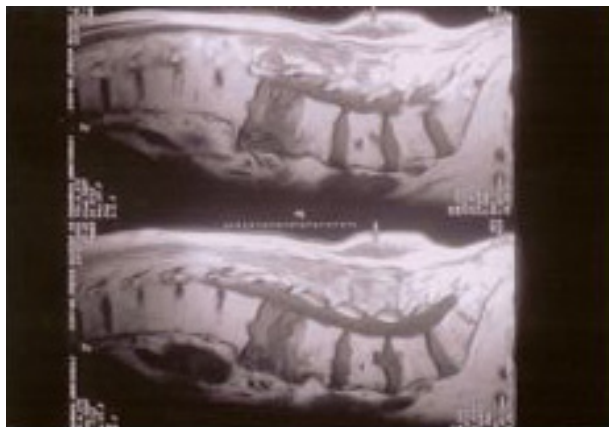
T2-weighted magnetic resonance imaging demonstrating destruction of the vertebral bodies of L2-L4.
